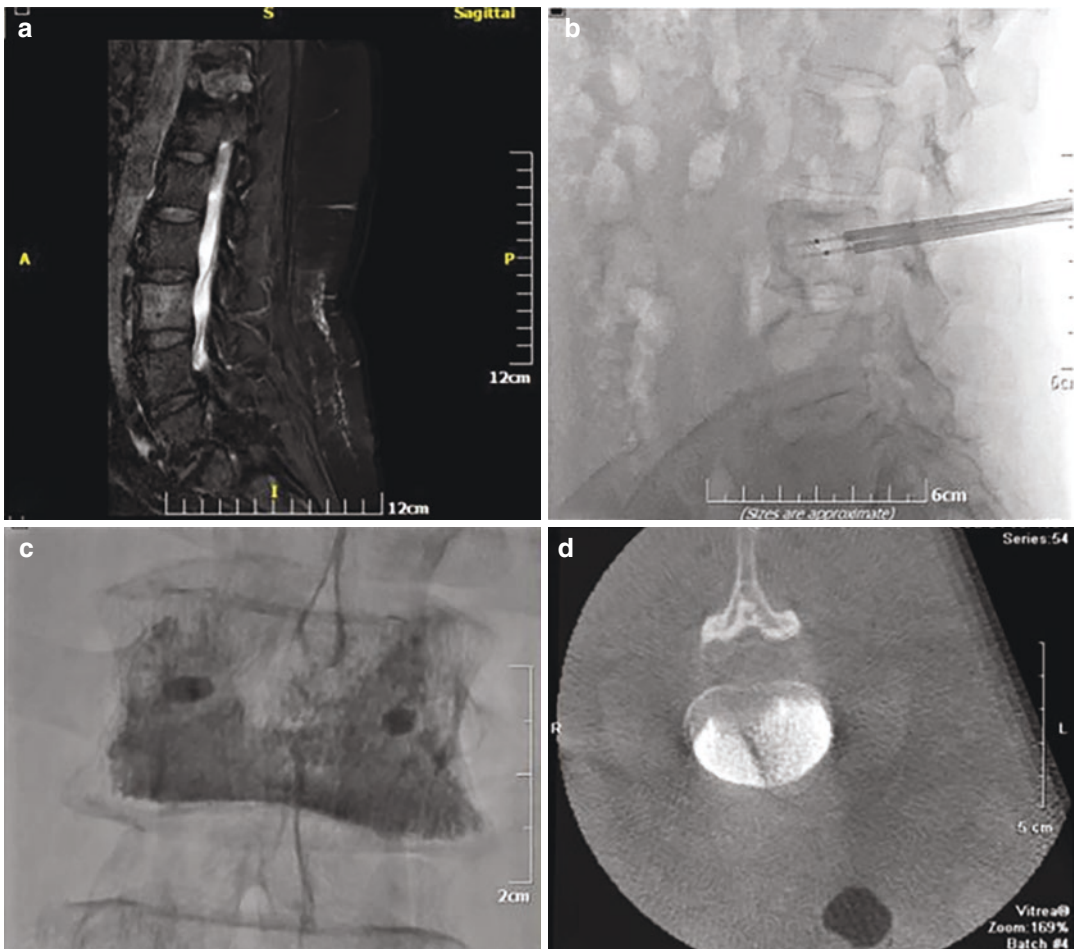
A female breast cancer oligometastatic patient with a solitary L3 vertebral body metastasis. (a) T1-weighted sagittal fat suppression MRI shows lesion's uptake and enhancement. (b) Fluoroscopy lateral view shows two bipolar radiofrequency electrodes placed
